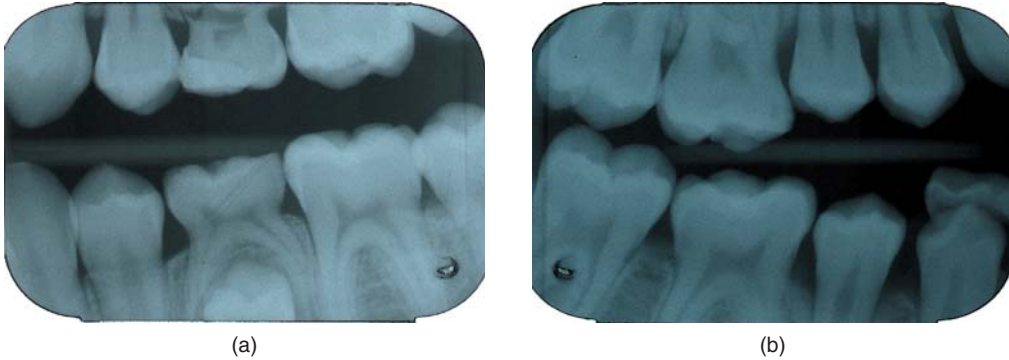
(a) Bitewing radiograph showing caries limited to outer half of enamel in maxillary left first permanent molar. (b) Bitewing radiograph showing lesion in outer third of dentin in maxillary right first permanent molar.
